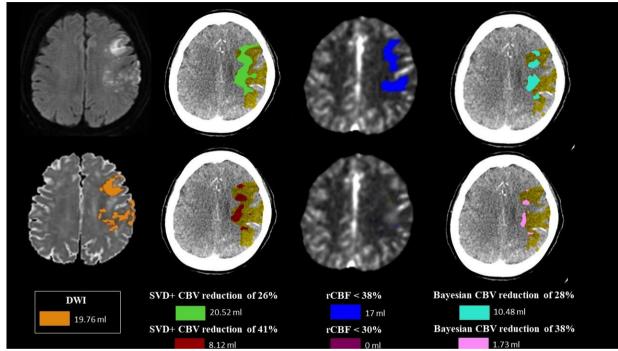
A 74 year-old woman with right hemispheric stroke. The initial NIHSS score was 17 and the time between CTP to MRI was 37 min. The infarct core volume was estimated 17.76 ml with DWI-ADC (orange color). The CTA demonstrates occlusion of the left M1 MCA. The infarct core volume was calculated 8.17 ml on SVD+ VITREA CBV reduction of 41% (red color), 20.52 ml on SVD+ VITREA CBV reduction of 26% (green color), 1.73 ml on BAYESIAN VITREA CBV reduction of 38% (pink color), 10.48 ml on BAYESIAN VITREA CBV reduction of 28% (turquoise color), 0 ml on RAPID rCBF < 30% (purple color), and 17 ml on RAPID rCBF < 38% ml (blue color).
